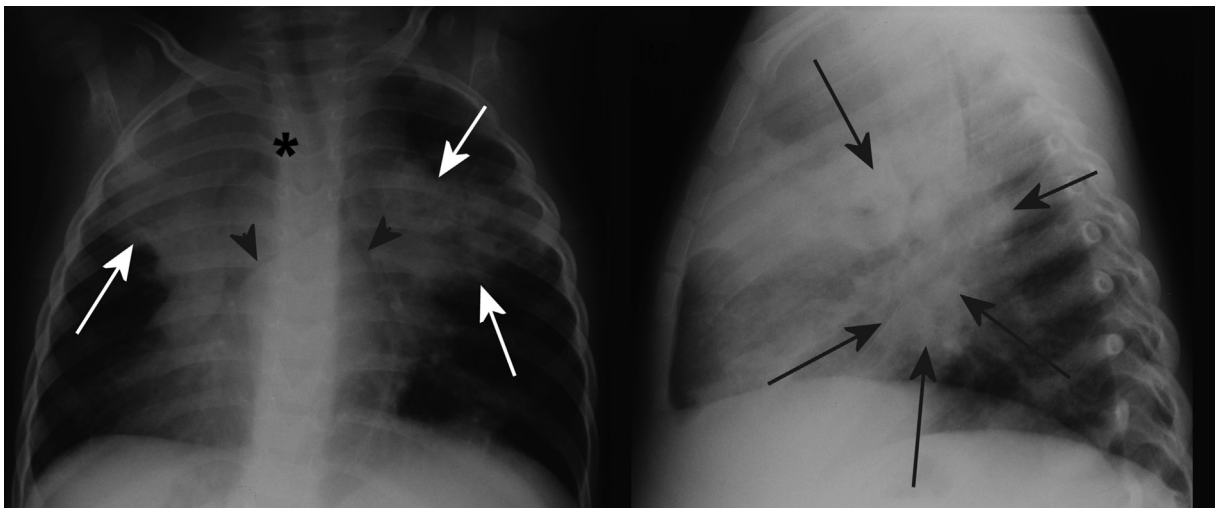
Frontal and lateral chest radiographs of a 2.5-year-old well-nourished girl with confirmed TB, who was HIV-negative, demonstrating paratracheal lymphadenopathy (asterisk) as seen by tracheal displacement to the left, compression of the bronchus intermedius as well as left main bronchus (arrow heads) and multi-lobar air space consolidation (white arrows). The doughnut sign (black arrows) on the lateral view indicates peri-hilar lymphadenopathy.
